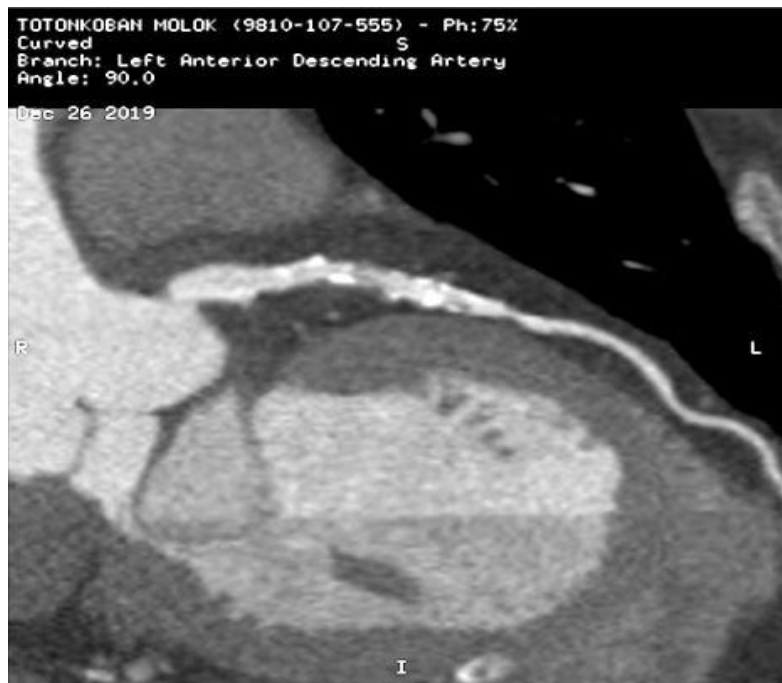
Coronary CT Angiography, Left Anterior Descending Artery
